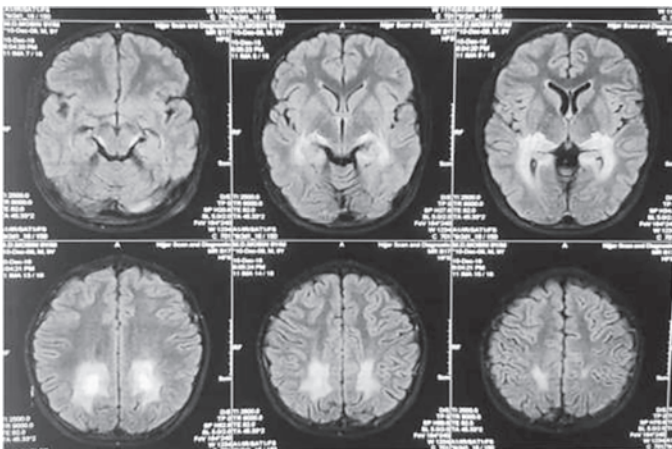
FLAIR images show Posterior predominant white matter involvement. Lowe score for this patient- 9-10.
